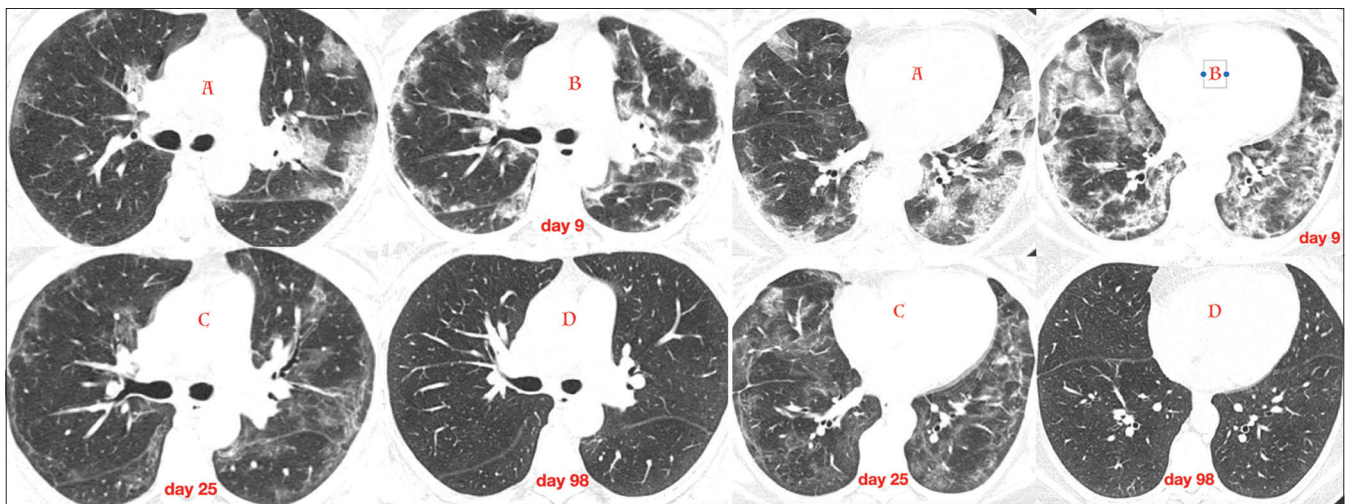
(A-D): HRCT (A) typical peripheral ground-glass and consolidations in subpleural regions. HRCT (B) 9 days after first scan evolve into consolidations, reticular abnormalities resembling organising pneumonia. HRCT (C) 25 days after first scan consolidations resolved with minimal ground-glass densities and subpleural curvilinear lines. HRCT (D) CT study at day 98 from first scan reveals total clearing of all abnormalities also subpleural curvilinear lines which is often reported as fibrosis
